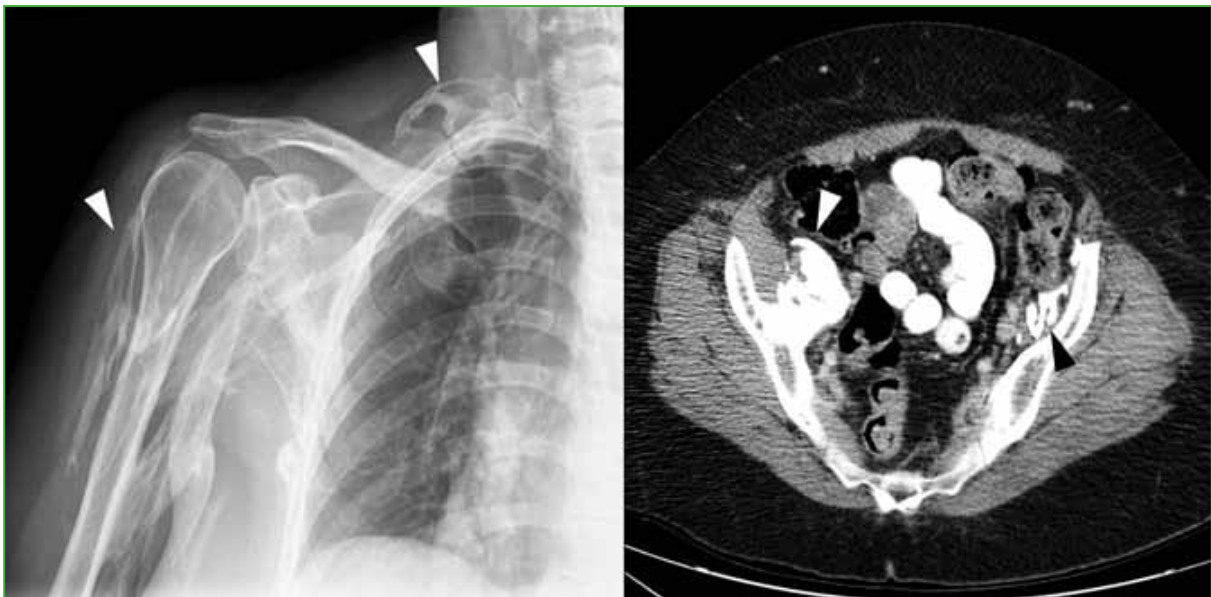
Myositis ossificans progressiva. On the right shoulder radiograph, multiple soft tissue calcifications are recognized, and on computed tomography, progressive calcifications are seen in the psoas.
